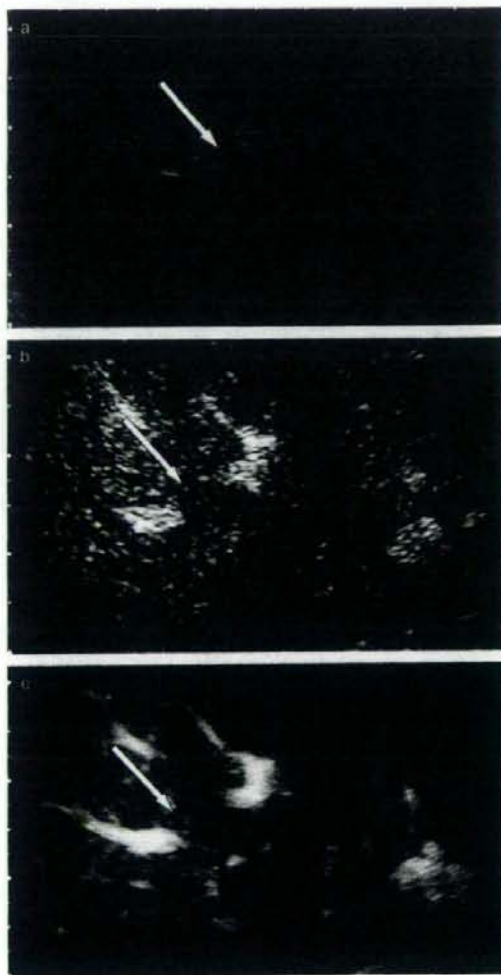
A 77-year-old woman with a 10-mm-diameter, well-differentiated hepatocellular carcinoma (HCC) in the right lobe of her liver. (a) Baseline ultrasound image show a focal hypoechoic HCC (arrow) in the right hepatic lobe. (b) Conventional harmonic image obtained during the portal venous phase—that is, 46 s after injection of the microbubble contrast agent—shows HCC (arrow) with an iso or slightly hypoechoic appearance relative to the adjacent liver. (c) Microflow image obtained during the portal venous phase—that is, 50 s after injection of the microbubble contrast agent—shows the blood vessel architecture more distinctly than the conventional harmonic image. Border between the tumoral and normal regions is not distinct. Blood vessel architecture in the tumoral region is almost identical with that in the adjacent normal hepatic parenchyma. Properties are characteristic of the normal pattern.
